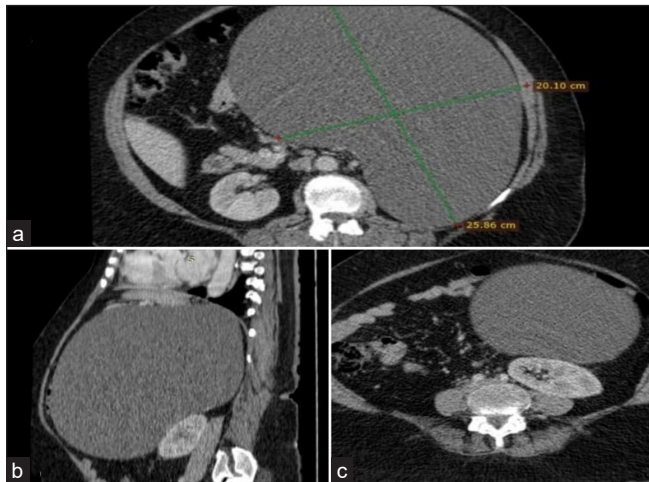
CT-Scan Abdomen with IV-Contrast. Panel (a) Axial view of CT-Abdomen IV contrast showing huge left-sided cyst 25*20 cm with no solid component and septations with few areas of calcifications. Panel (b) Sagittal View of CT-Abdomen IV contrast showing huge cyst arising from left adrenal gland displacing pancreas superiorly and kidneys inferiorly. Panel (c) Axial view of CT-Abdomen showing cyst compressing the left kidney.
